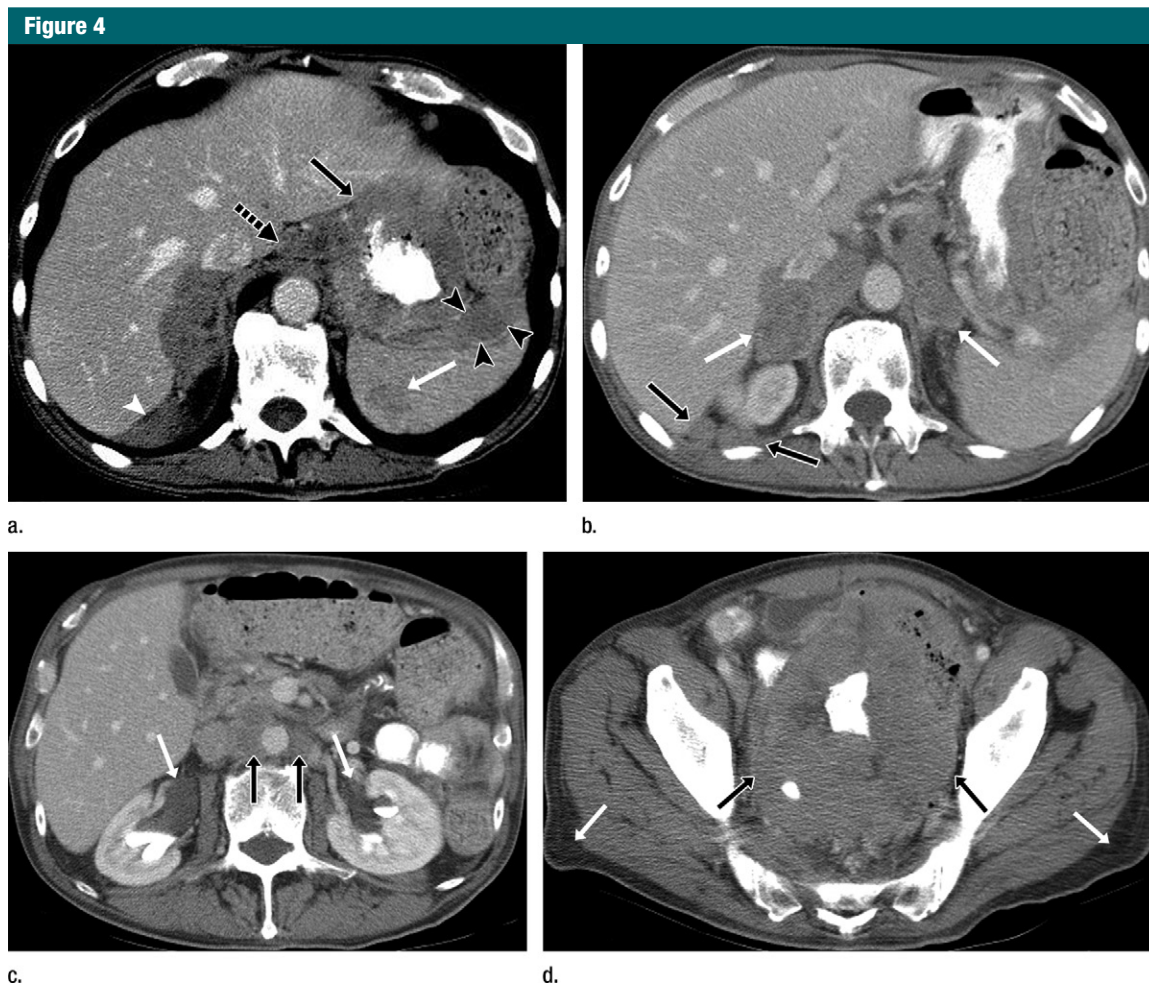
Images in a 78-year-old man who presented with diarrhea and weight loss. Axial CT images of abdomen and pelvis acquired with oral and intravenous contrast material raised concern for new diagnosis of lymphoma because of (a) hypoattenuating mass in spleen (white arrow), extensive thickening of stomach wall (black arrow), and soft-tissue masses adjacent to left hepatic lobe (dashed black arrow), posterior to right hepatic lobe (white arrowhead), and adjacent to spleen (black arrowheads); (b) masses in adrenals (white arrows) and soft-tissue nodules posterior to right kidney (black arrows); (c) retroperitoneal lymphadenopathy (black arrows); and (d) large pelvic mass from extensive bowel wall thickening (black arrows). Pelvic mass caused bilateral hydronephrosis (white arrows in c) from compression of distal ureters. Diffuse anasarca (white arrows in d) is noted.
